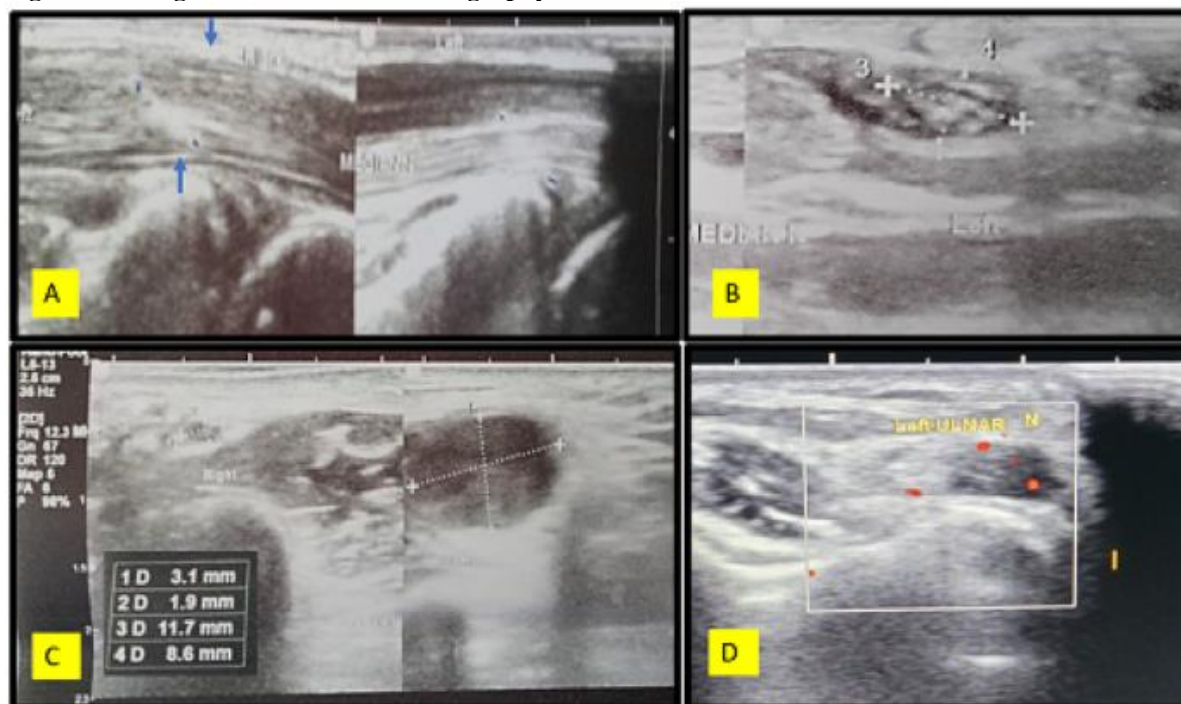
Images of nerves on ultrasonography
